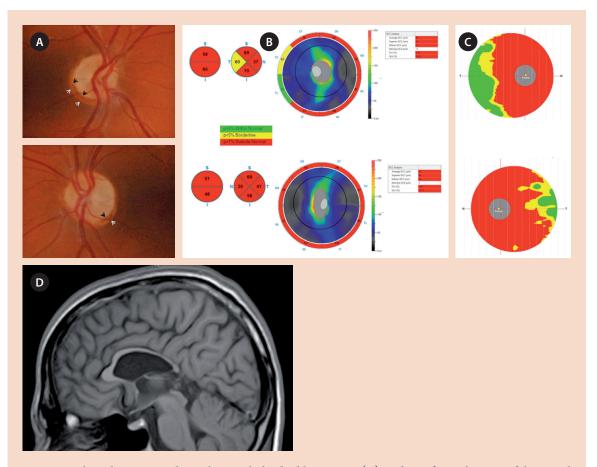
Bilateral optic nerve hypoplasia with the double ring sign (A), and significant thinning of the retinal nerve fibre layer (B) and macular ganglion cell complex (C) measured by Optovue optical coherence tomography. The FLAIR magnetic resonance imaging (D) shows a progressive thinning of the corpus callosum from the genu to the splenium.
